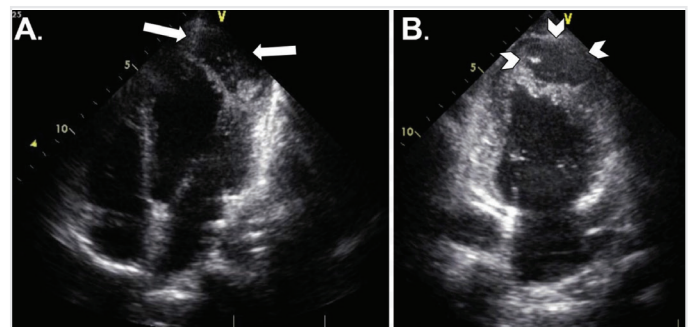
(Patient 7*) A 22 year-old male patient with Gharbi type 1 cyst of the left ventricular apex. The cyst is heterogeneous and hypoechoic on transthoracic echocardiography (arrows, A: arrowheads, B)
